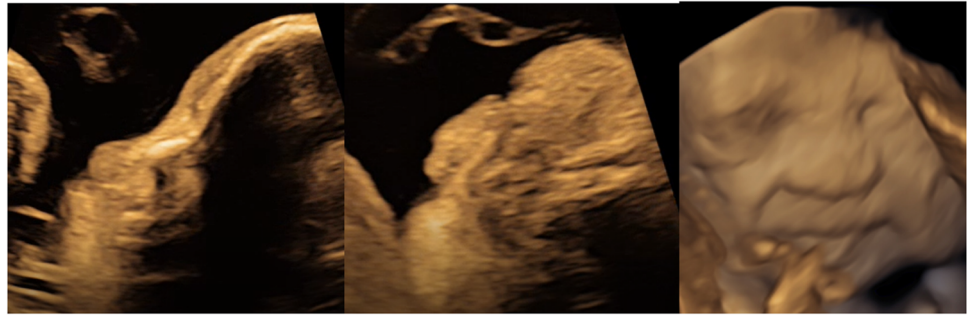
Surface rendering 4D image antenatal ultrasound (Case 2) showing distinctive facial features for Binder phenotype. Midface hypoplasia, hypoplastic and abnormal nasal bones, flattened nasal bridge, abnormal columella at 29 weeks of gestation
